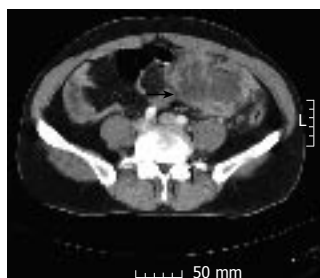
CT abdominal scan showing the presence of a solid fluid-containing tumor in the left lower quadrant (arrow).
